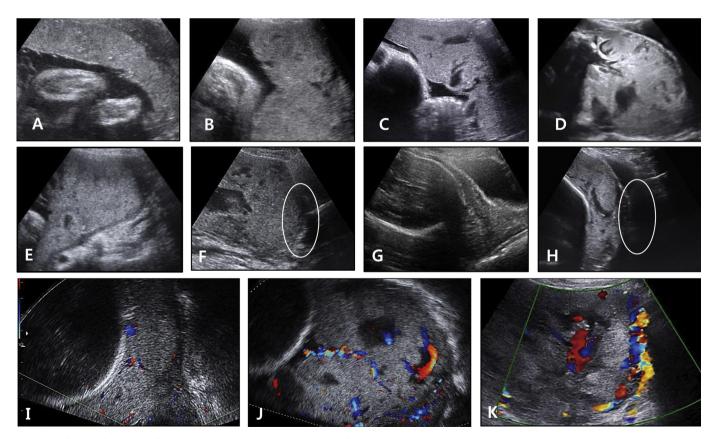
Classification of ultrasound findings. Lacunae within placenta were classified from Grade 0 to Grade 3 (A–D). Echolucent area between uterus and placenta was classified as intact or absent (E, F) and bladder wall–uterine interface was classified as intact or interrupted (G, H). The vascularity of placenta on color Doppler was classified as normal, moderately increased intraplacental vascularity and severe uteroplacental hypervascularity (I–L).
